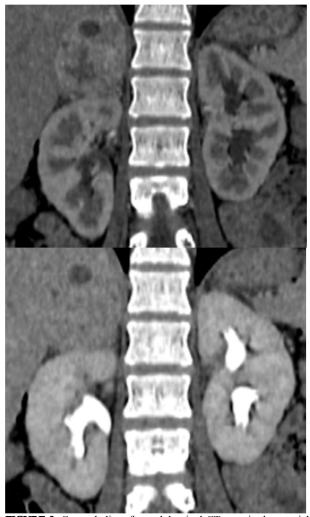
Coronal slices from abdominal CT scan in the arterial phase (a) and delayed venous phase (b), showing the previously described findings.
